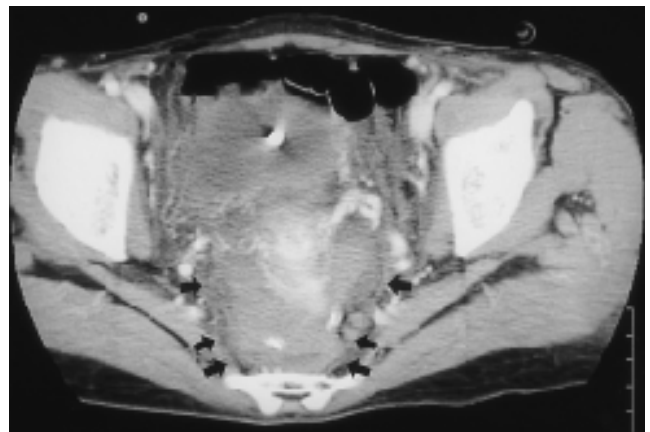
54-year-old woman with hemoperitoneum which developed after laparoscopic low anterior resection. Contrast-enhanced CT scan shows hyperattenuated hemorrhagic fluid collection (arrows) in the pelvic cavity.
